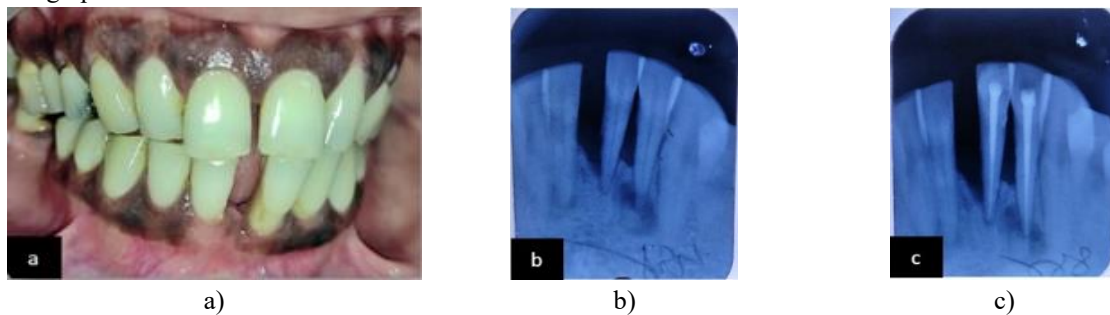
a) preoperative image displaying pathological migration and clinical attachment loss in tooth 31; b) intraoral periapical radiograph showing extensive alveolar bone resorption extending to the apex of the mandibular left central incisor, along with an indistinct periapical radiolucency of approximately 5 mm near the left mandibular lateral incisor; c) post-root canal treatment status of teeth 31 and 32.
